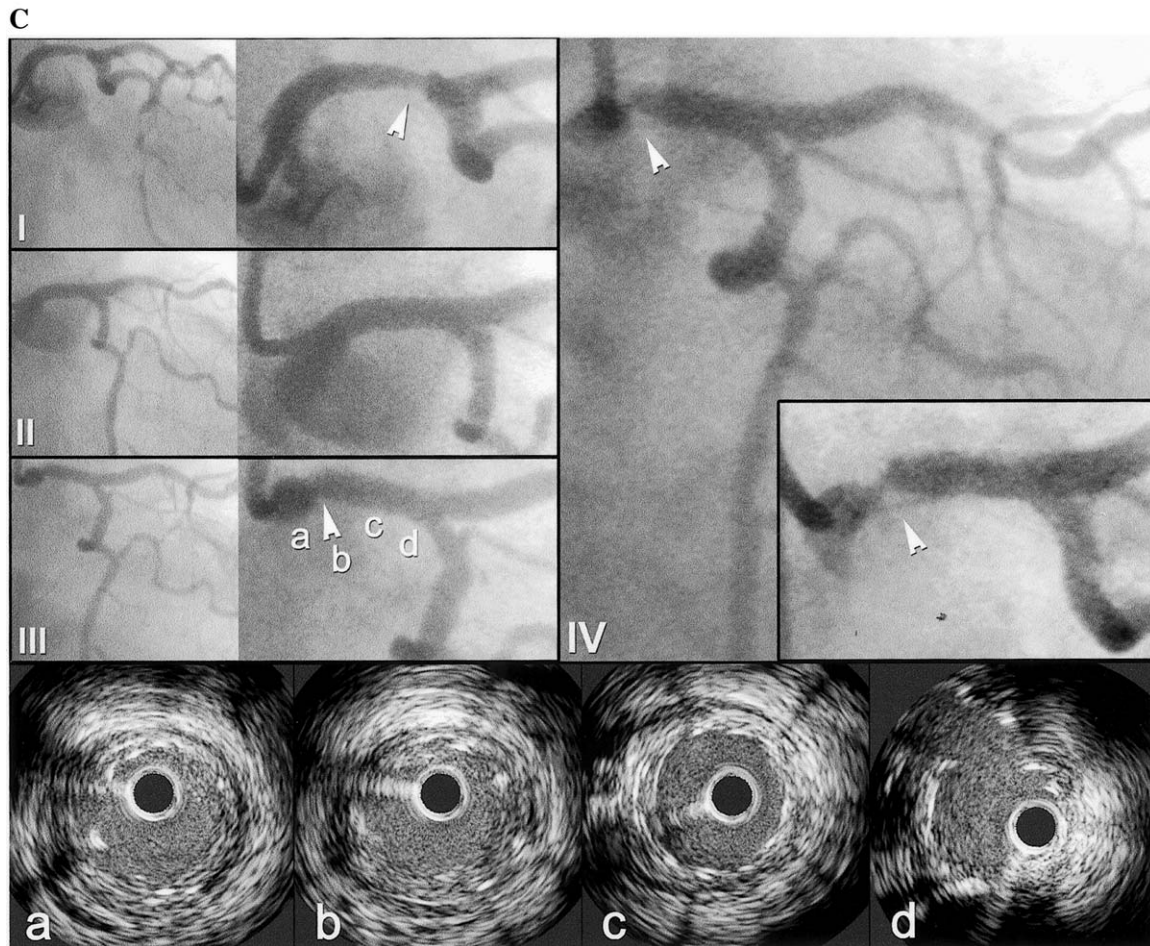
Continued. (C) Sequential coronary angiographies showing the left main coronary artery (magnified at the right) and the proximal and mid-tract of circumflex and anterior descending arteries of Patient #13. Panel I: A stenosed distal left main coronary artery with its magnification in the right quadrant and a suboccluded circumflex artery are visible before treatment. Panel II: Angiographic result immediately after treatment. At six months (panel III), a moderate focal restenosis in the proximal tract of the left main coronary artery was present (arrowhead) that did not cause significant obstruction of the lumen at intravascular ultrasound (IVUS) investigation (lower panel) and did not result to be flow-limiting, with a fractional flow reserve of 0.85. At 12 months (panel IV), control angiogram revealed a tight in-stent restenosis (arrowhead), magnified in the insert, through which the IVUS probe could not be negotiated and required reintervention. Lower panel is showing four IVUS cross-sections (Atlantis 40 Mhz, Boston Scientific, Natick, Massachusetts) from the left main coronary artery at six months: (a) proximal edge of the stent in the left main coronary artery, with a malapposed strut visible at 7 o'clock; (b) in-stent concentric growth of intimal hyperplasia at the minimal lumen area; (c) minor degree of in-stent eccentric hyperplasia located in the mid-tract of the left main coronary artery at 9 o'clock; (d) left main coronary artery carina, showing no sign of intimal hyperplasia, with the stented circumflex artery originating at 11 o'clock.
